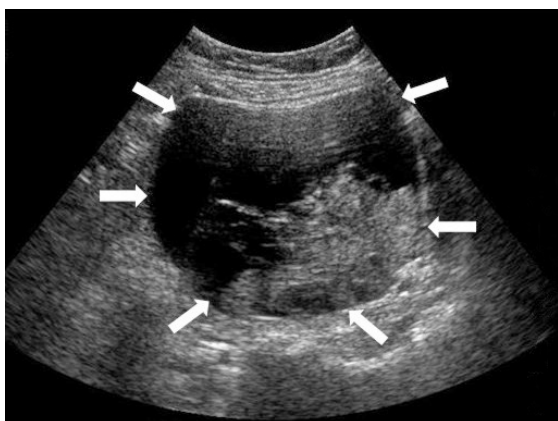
Transabdominal pelvic ultrasonography image of a 61-year-old woman with cervical carcinoma shows a complex solid-cystic 9.4 cm × 8.1 cm left adnexal mass (white arrows). Blood flow was visible within the solid hypoechoic component on colour Doppler. The patient underwent left salpingo-oophorectomy and was found to have concurrent endometrioid cystadenocarcinoma of the left ovary. Her cervical carcinoma was treated with radiotherapy and chemotherapy.
